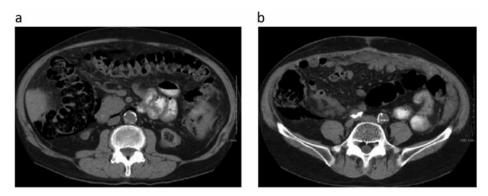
CT scans of the abdomen showing extensive pneumatosis intestinalis of the of the right and transverse colon.
